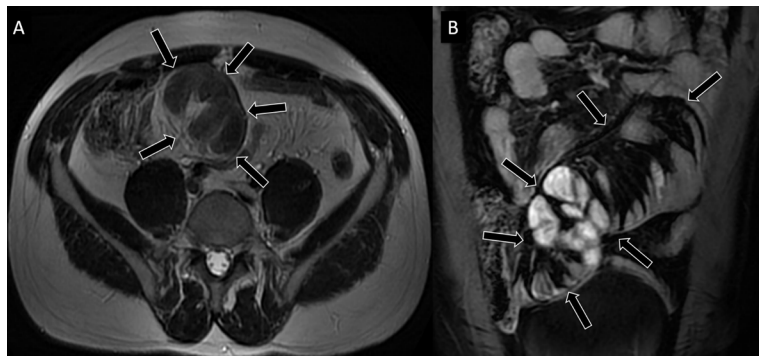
Axial T2-weighted (A) and coronal FIESTA (B) MR images showing a hypointense membranous structure (arrows) in keeping with sclerosing encapsulated peritonitis.
